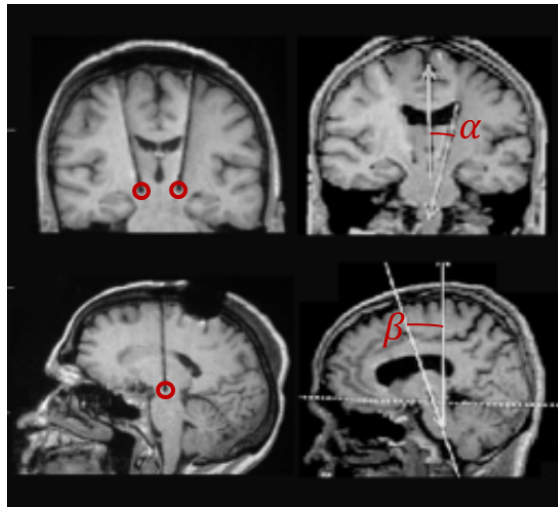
Magnetic resonance images demonstrating the procedure to localize the implanted electrodes. *Left*: identification of the limit of the distal artifact on coronal (*upper*) and sagittal (*lower*) slices, following the main axis of the electrode. *Right*: measurement of the angles (α , β) between the electrode and the vertical plane in coronal (*upper*) and sagittal (*lower*) slices. Adapted from [2].
